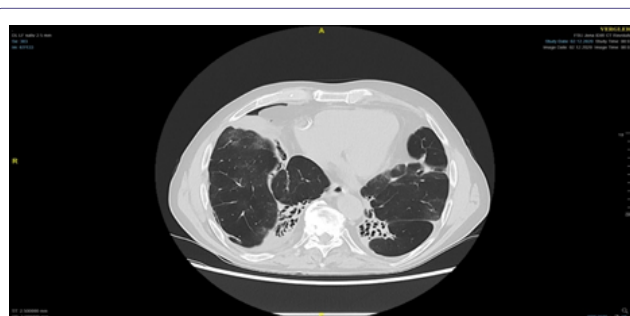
Non-contrast-enhanced chest CT on day 10: Ventral pneumothorax reduced by 50% (7 mm on day 10 compared to 14mm on day one).
